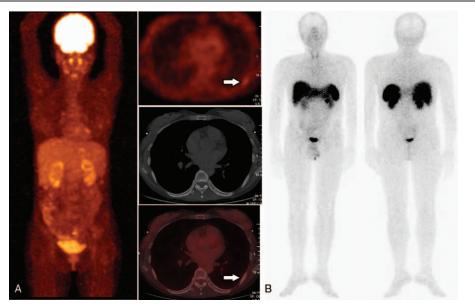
<sup>18</sup>F-FDG PET/CT only showed a mild uptake in the seventh rib which might be an insufficiency fracture (arrow) while the result of <sup>99m</sup>Tc-OCT was negative. <sup>18</sup>F-FDG PET/CT=fluorodeoxyglucose positron emission tomography/computed tomography, <sup>99m</sup>Tc-OCT=technetium-99m octreotide.
